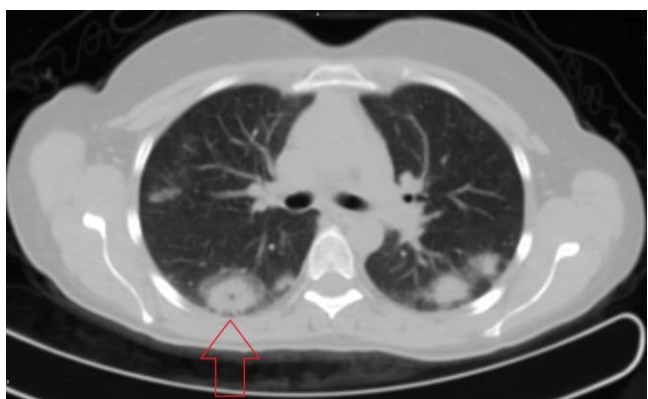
Thoracic CT showing widespread nodular opacities in both lung
